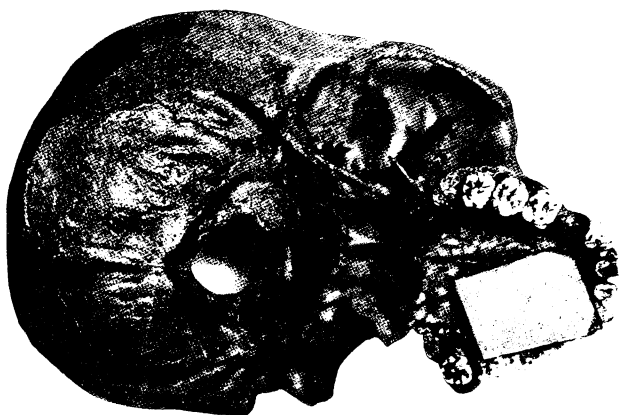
Position of the film in the mouth for making radiographs of the upper bicuspid and first molar region.
